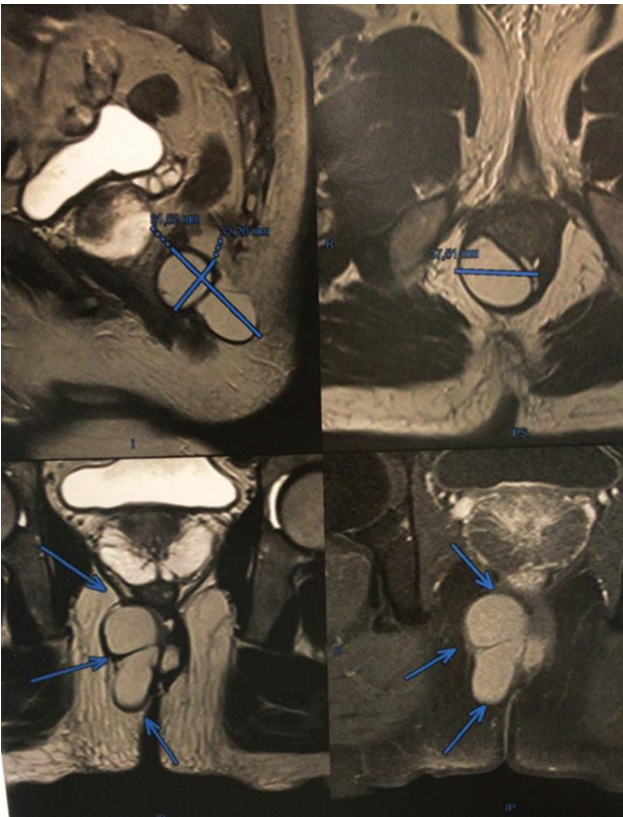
Magnetic resonance imaging of the pelvis (perianal), with cystic lesion.
